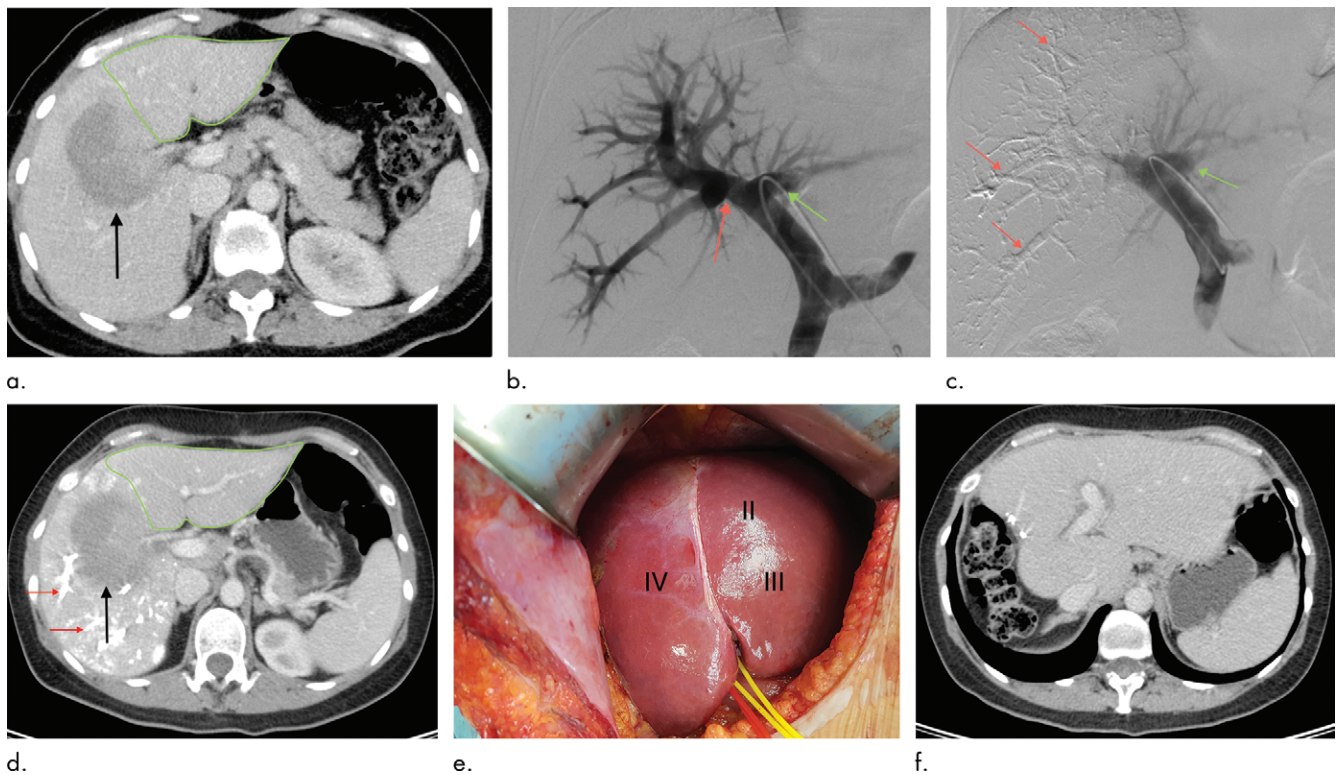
Main stages of a participant in the Best Future Liver Remnant, or BestFLR, trial, a 41-year-old woman with single large right liver metastasis from adenoid cystic carcinoma. (a) Contrast-enhanced portal venous phase CT scan in axial plane shows right liver metastases (arrow) and left liver (future liver remnant [FLR]) outlined in green) before right portal vein embolization (PVE). (b) Portography immediately before PVE shows normal portal vein anatomy. Red arrow indicates right portal vein, and green arrow indicates left portal vein. (c) Final portography shows occlusion of right portal vein branches with N-butylcyanoacrylate (NBCA) plus iodized oil (red arrows) and patent left portal vein (green arrow). (d) Contrast-enhanced CT scan in axial plane 14 days after PVE shows FLR hypertrophy (outlined in green). Notice hyperattenuated NBCA plus iodized oil inside right portal vein branches (red arrows) and right liver tumor (black arrow). (e) Intraoperative aspect of left liver after right hepatectomy (liver segments II, III, and IV). (f) Axial contrast-enhanced CT scan 1 year after hepatectomy shows no tumor recurrence.
